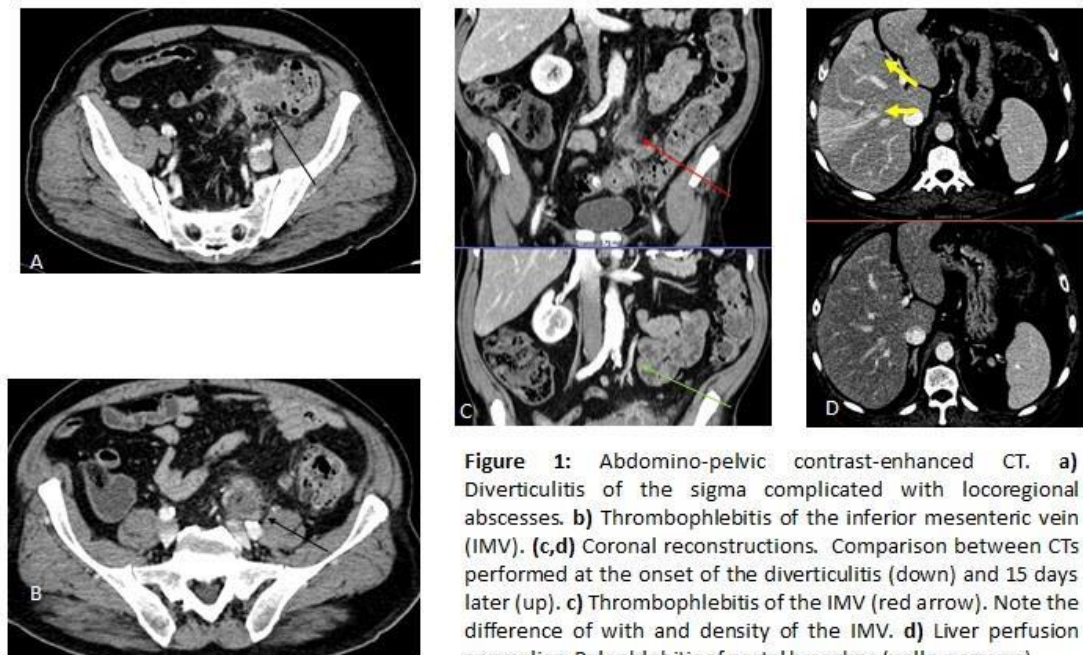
Abdomino-pelvic contrast-enhanced CT. a) Diverticulitis of the sigma complicated with locoregional abscesses. b) Thrombophlebitis of the inferior mesenteric vein (IMV). (c,d) Coronal reconstructions. Comparison between CTs performed at the onset of the diverticulitis (down) and 15 days later (up). c) Thrombophlebitis of the IMV (red arrow). Note the difference of with and density of the IMV. d) Liver perfusion anomalies. Pylephlebitis of portal branches (yellow arrows).
